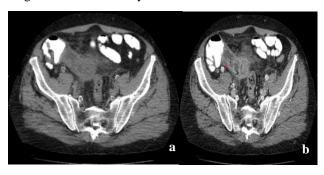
Case 5- axial unenhanced (a) CT scan shows prominent appendix with heterogeneous attenuation. Periappendiceal fat stranding is seen (white arrow). Axial contrast-enhanced (b) CT scan shows enhancing mural nodularity (red arrow) with internal separation (black arrow).
